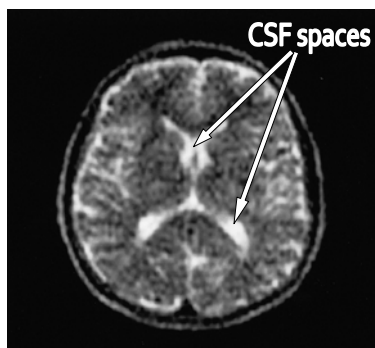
CSF spaces on an MRI image of the brain. On this MRI scan, the CSF space is represented as bright areas; those are found in the central regions of the brain. (Arrows and text added).
